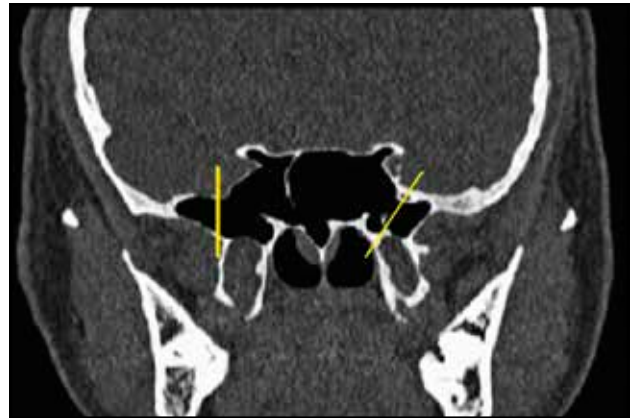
Greater wing extension type on the left side- pneumatization laterally on the sphenoid sinus wall (cranio-facial CT scan, coronal slice; yellow line – along the vidian canal and the medial margins of the foramen rotundum).
